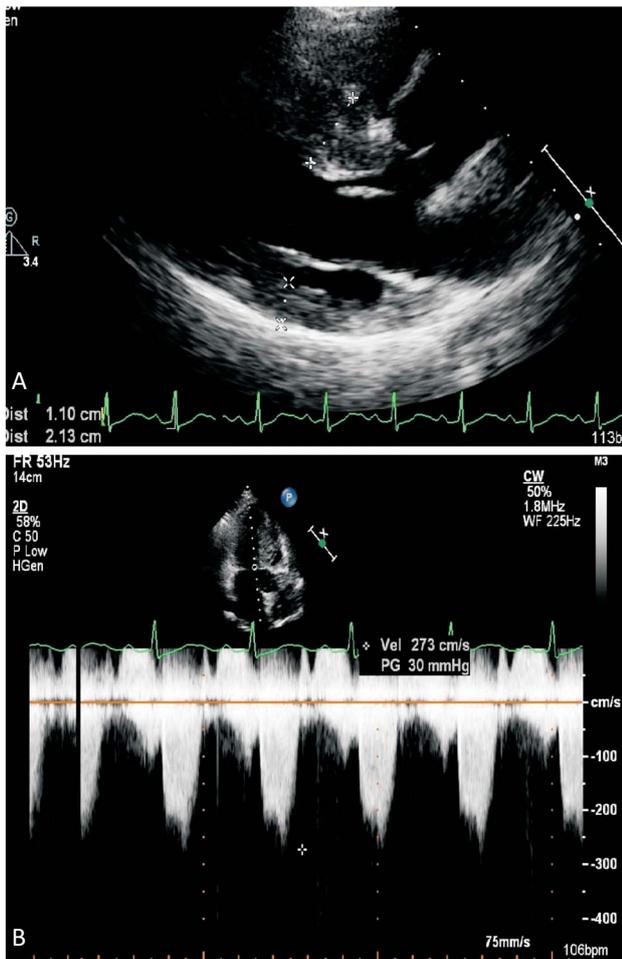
Transthoracic echocardiography images. (A) Septal and posterior wall thicknesses. (B) Resting left ventricular outflow tract peak gradient.
